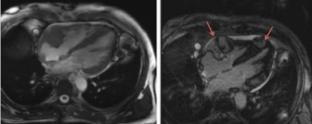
Cardiac MRI identified a solid, heterogeneous mass, with areas of late gadolinium enhancement, located in lateral wall of right atrium extended to atrioventricular sulcus and lateral wall of right ventricle, encroaching posterior leaflet of tricuspid valve with 7.3x4.4x8 cm; another intramyocardial lesion in apical segment of septum, as well as, basal thickening of anterior wall.
